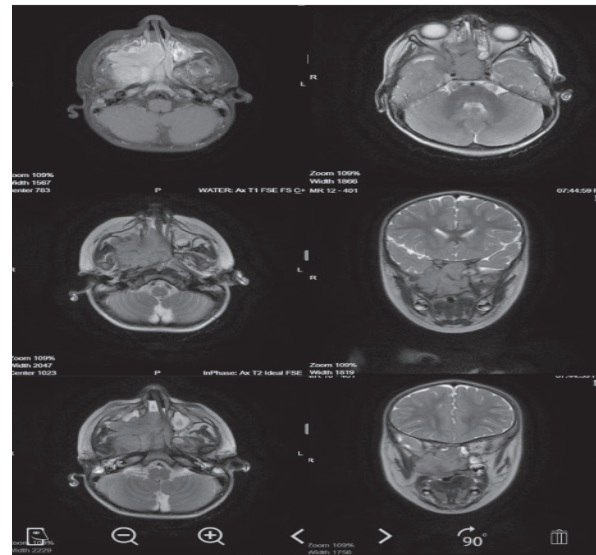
MRI Showing Large Extensive Soft Tissue Mass Involving Right Maxillary Sinus, Sphenoid Sinus, Right Nasal Cavity
